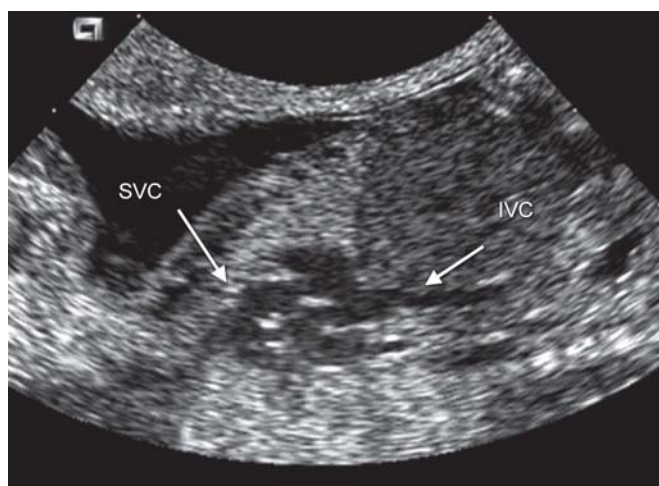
Early fetal echocardiography by 2D in a structurally normal heart. Systemic venous return to the right atrium throws the superior and inferior vena cava. SVC: superior vena cava; IVC: inferior vena cava
